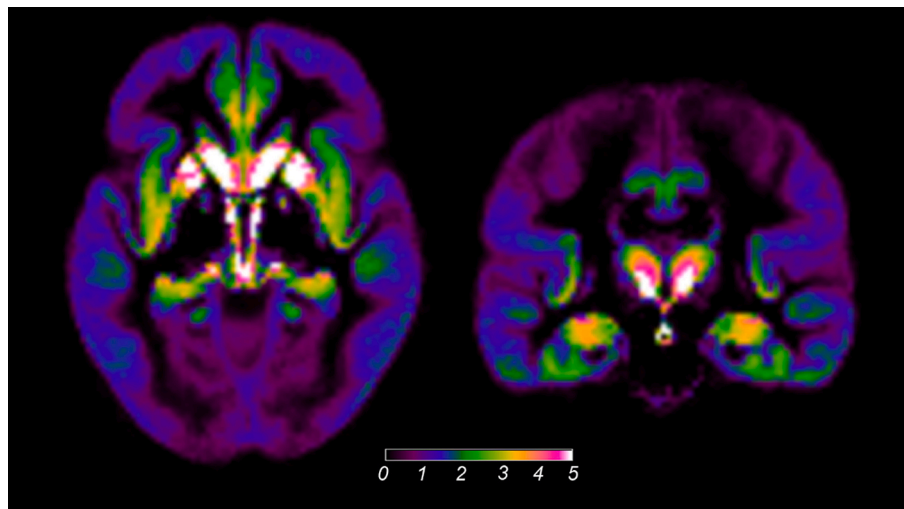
Mean SUVR images of ¹⁸F-THK5351 in cognitively normal older adults. SUVR, standardized uptake value ratio.
